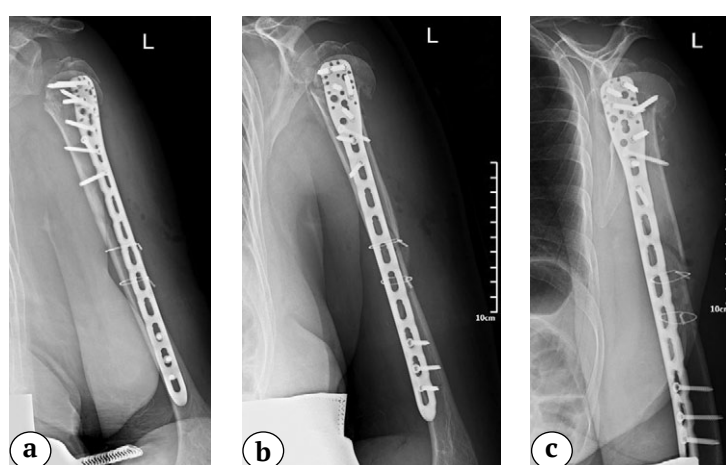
Postoperative X-ray's after osteosynthesis of the humerus with a PHILOS Long plate and cerclages: a – frontal view; b – lateral view; c – oblique view
